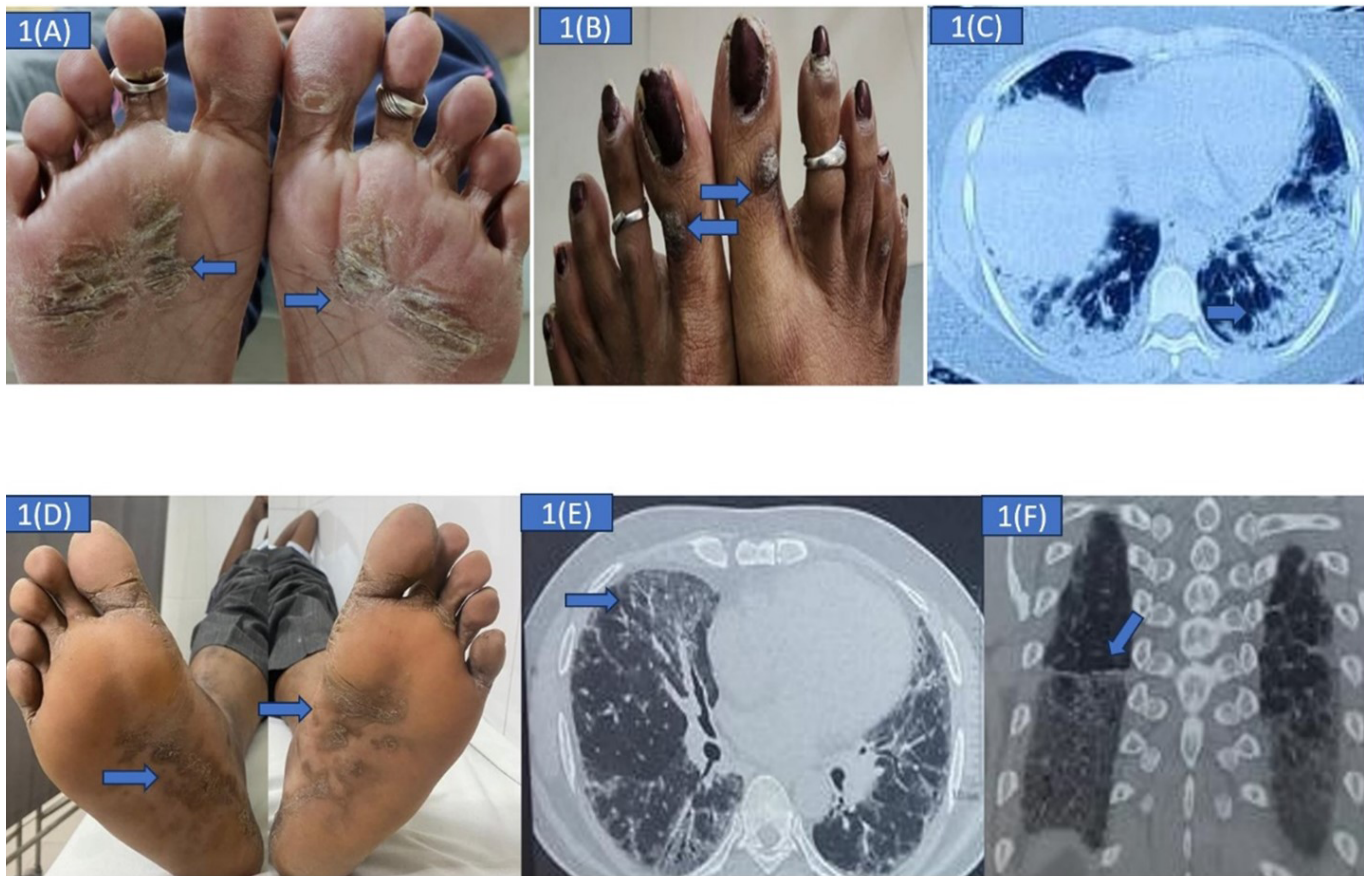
(A) Hyperkeratosis, fissuring on the plantar surface of both feet. (B) Hyperkeratosis on dorsal aspect of both great toes. (C) HRCT Chest s/o Organising Pneumonia pattern of ILD. (D) Hyperkeratosis on the plantar surface and medial aspect of both feet. (E,F) HRCT Chest s/o NSIP pattern of ILD, anterior upper lobe sign. (E) Straight edge sign.
